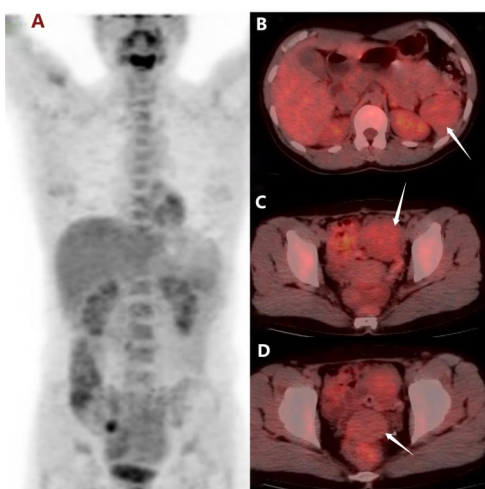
A; The whole-body PET image of case 2. B; DPL nodule anterior to the left kidney and the SUVmax is 1.9. C-D Some DPL nodules in the pelvic cavity and the SUVmax is 3.1.
